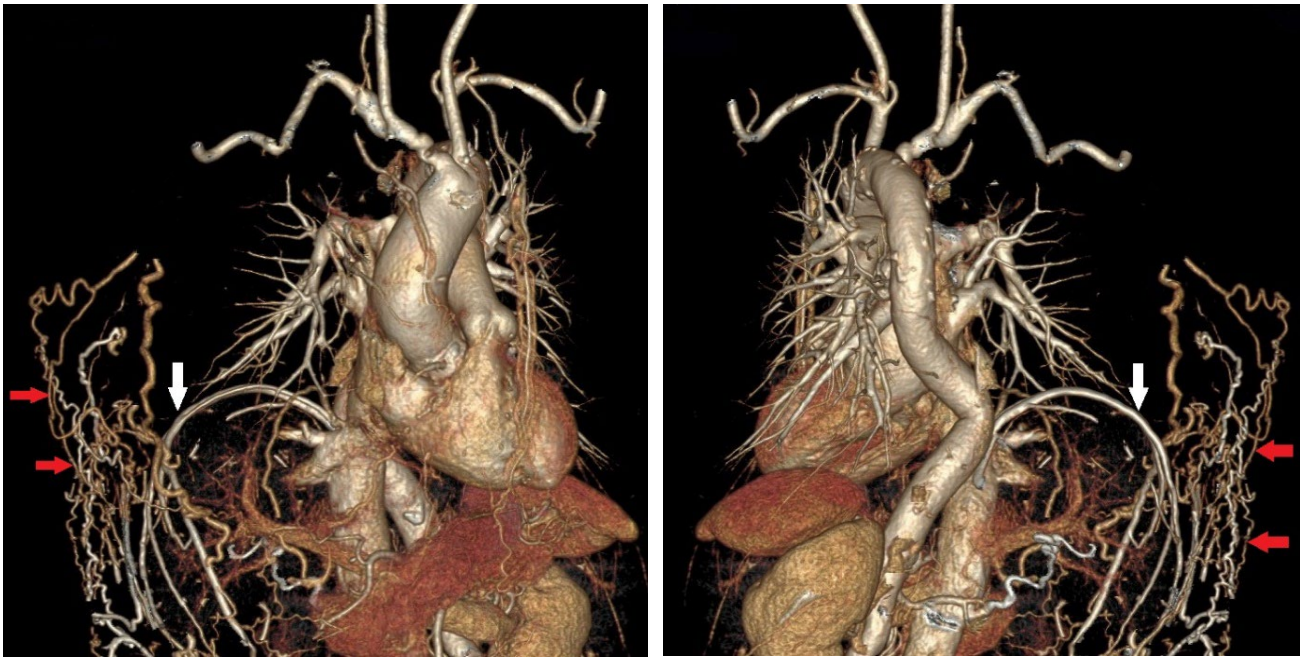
(Anterior view) and 1B(Posterior view): Three-dimensional (3D) reconstruction of chest CT image showed right phrenic collateral (White arrow) and chest wall collateral (Red arrows).
